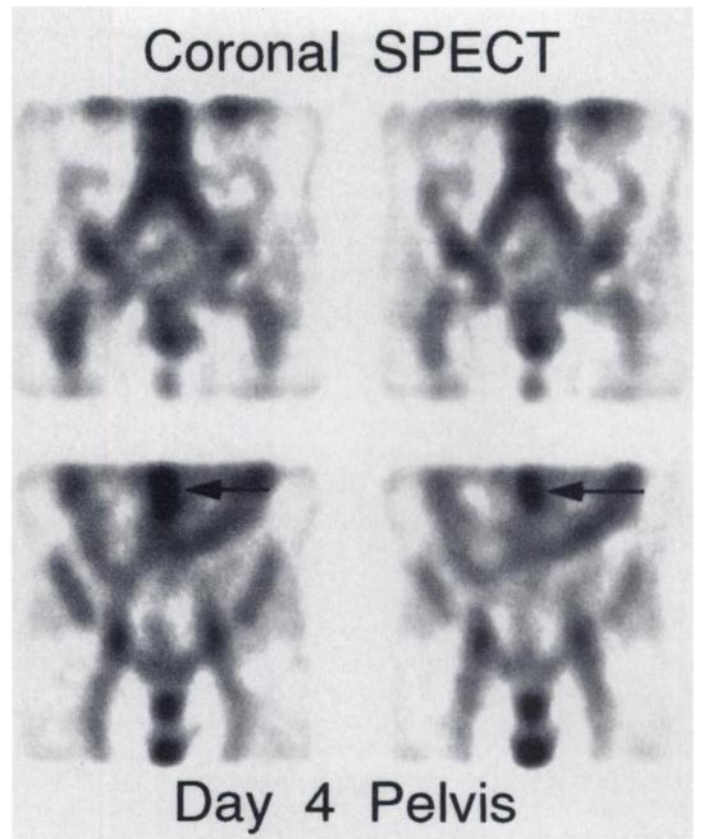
Day 4 coronal SPECT images of the pelvis. Arrows in the two lower images point to localization in lymph nodes near the aortic bifurcation.
